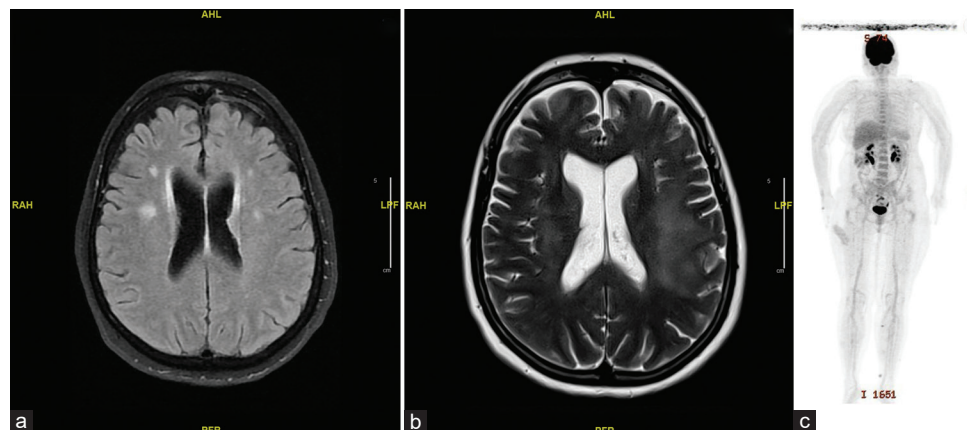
(a) Baseline brain magnetic resonance imaging (MRI) showing small hyperintense, nonenhancing white matter lesions in the bilateral periventricular areas on T2/fluid attenuated inversion recovery sequences. (b) Repeated brain MRI showing interval progression of the ill-defined, confluent T2 hyperintense signal abnormality in the supratentorial and infratentorial parenchyma. (c) Follow-up positron emission tomography-fluorodeoxyglucose 18 scan showing resolution of previously noted lower limb lesions
